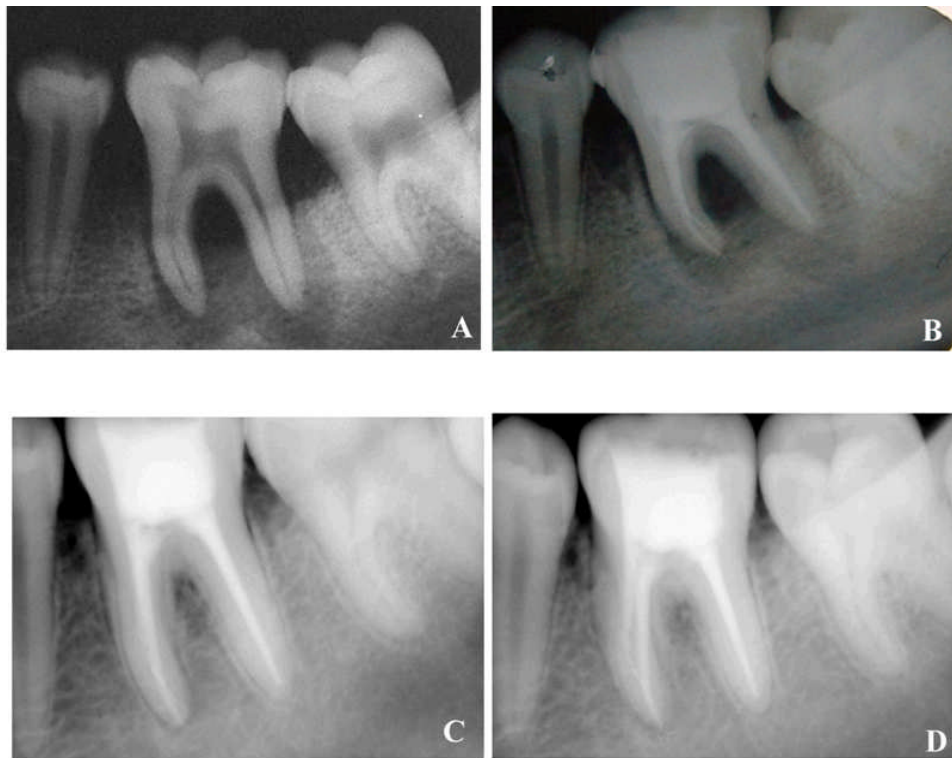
(A) Preoperative radiograph of tooth #19 extensive periradicular bone loss. (B) Radiograph taken upon completion of root canal treatment. (C) One year follow up radiograph showing evidence of bony healing (D) One year and six months follow-up X-ray film showing considerable bone apposition, probing depths were of no more than 3mm all around the tooth.
